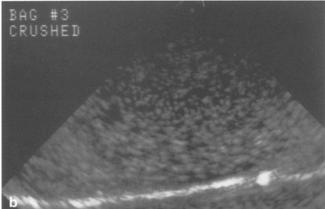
Sonographic appearance of sterile water before and after suspension of a crushed tablet of oxybutinin chloride. a Sterile water; b sterile water 5 min after introduction of crushed tablet
